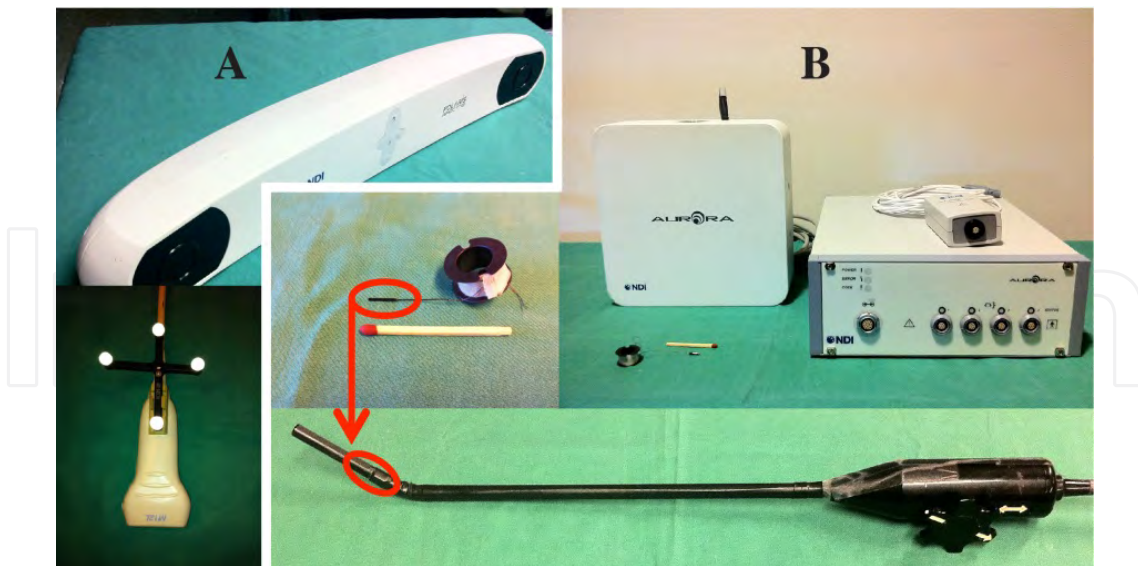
Optical (A) and electromagnetic (B) tracking of ultrasound probes.
